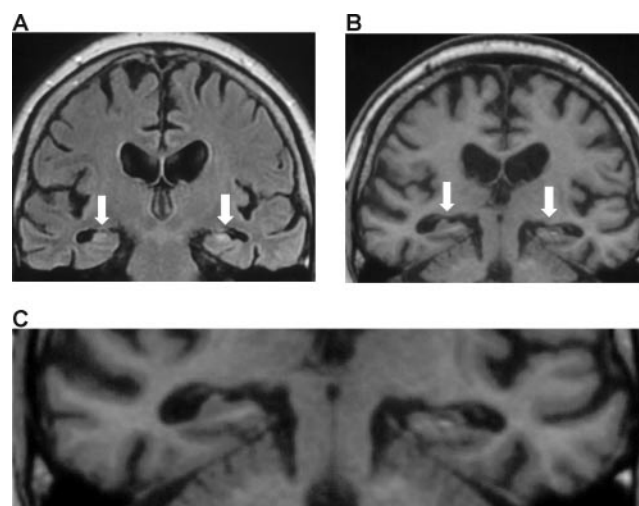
Coronal sections from the patient's structural MRI scan, with the white arrows indicating the atrophic hippocampi (see Methods for more details). (A) FLAIR image from a section through the anterior temporal lobes. (B) A T_1 image from a more posterior section. (C) A magnified view of TT's medial temporal lobes taken from his T_1 structural scan.
